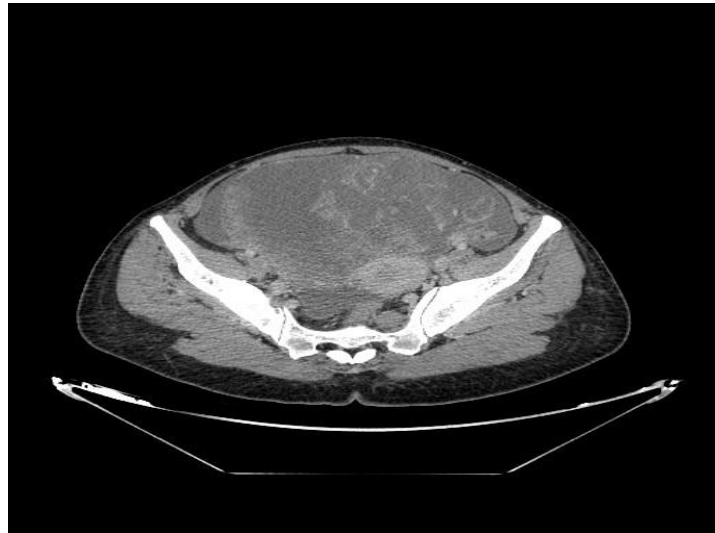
Pelvic floor CT scan showing a right latero-uterine mass.
